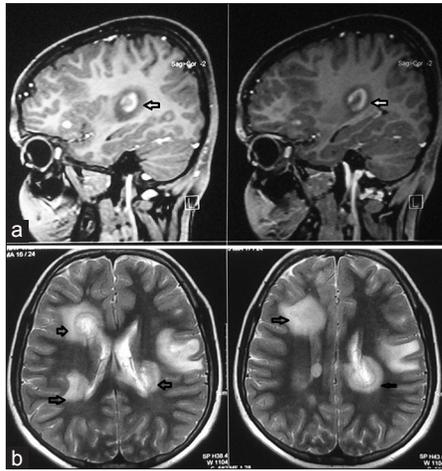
(a and b) T2-weighted magnetic resonance imaging postgadolinium contrast suggestive of multiple nodular lesions with peripheral enhancement in cerebral hemispheres, deep periventricular, and juxtacortical white matter (marked by arrows)
